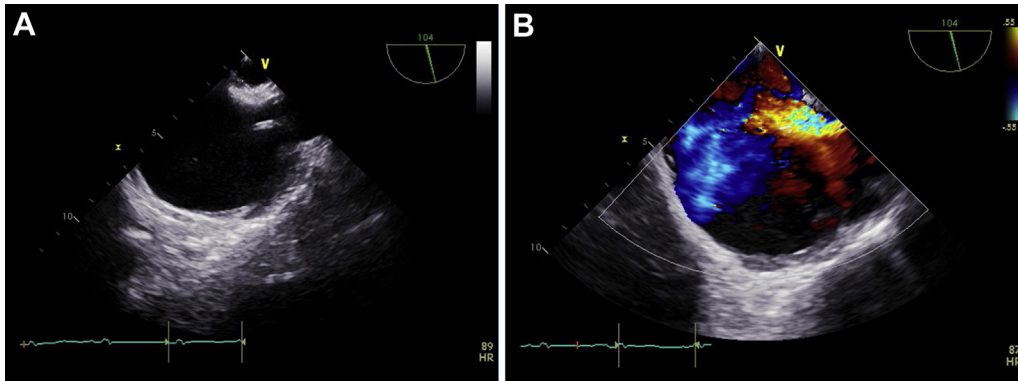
(A) Midesophageal bicaval view of the right atrium–superior vena cava junction with the extracorporeal membrane oxygenation (ECMO) return cannula positioned at this junction. (B) Color flow Doppler of ECMO cannula shows return flow jet directed toward the right atrium in close proximity to the interatrial septum.
